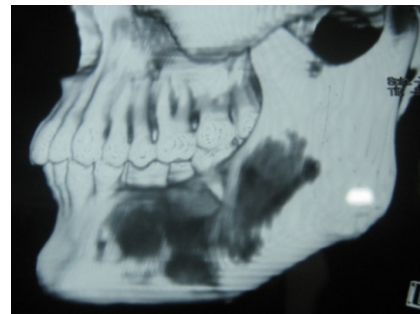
Three dimensional CT showing destruction of the buccal cortical plate
